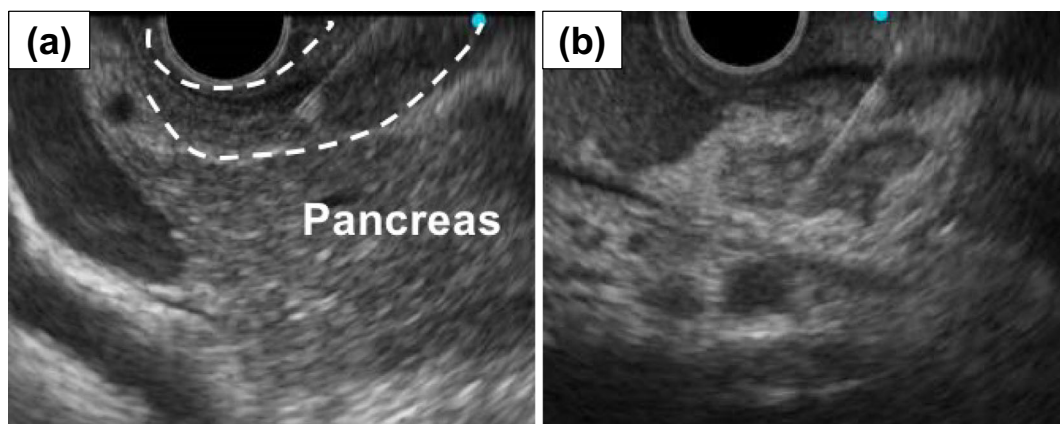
Endoscopic ultrasound-guided fine needle aspiration (EUS-FNA). EUS revealed duodenal thickening (a) and irregular abdominal lymph node swelling (b). FNA of both lesions was successfully performed using a 22 G needle.
